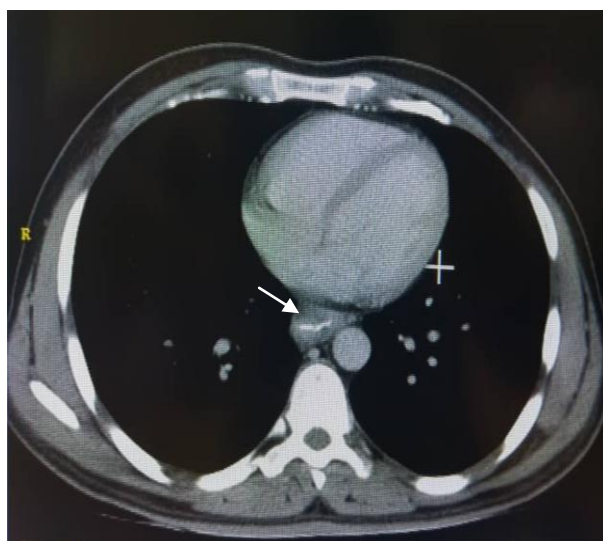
Computed tomography (CT) with a sharp chicken bone retrieved from the esophageal wall
